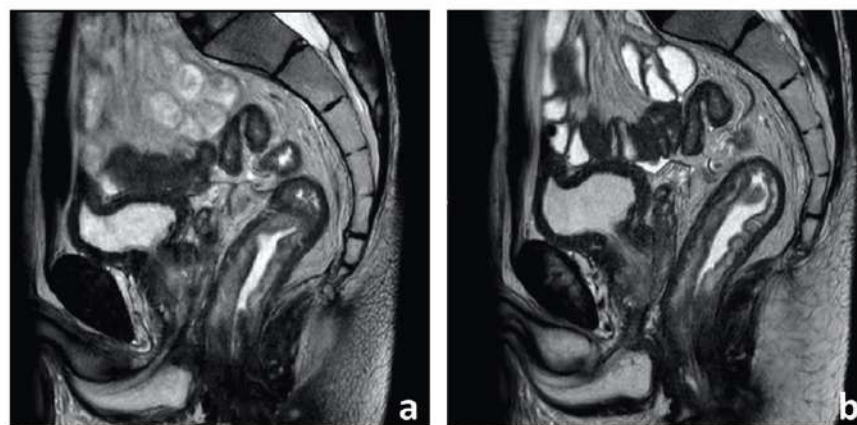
Sagittal T2-weighted images before (a) and 5 min after (b) IV administration of a spasmolytic agent (butylscopolamine 20 mg). Notice how the walls of the rectum and small bowel are much better defined due to limited peristalsis
